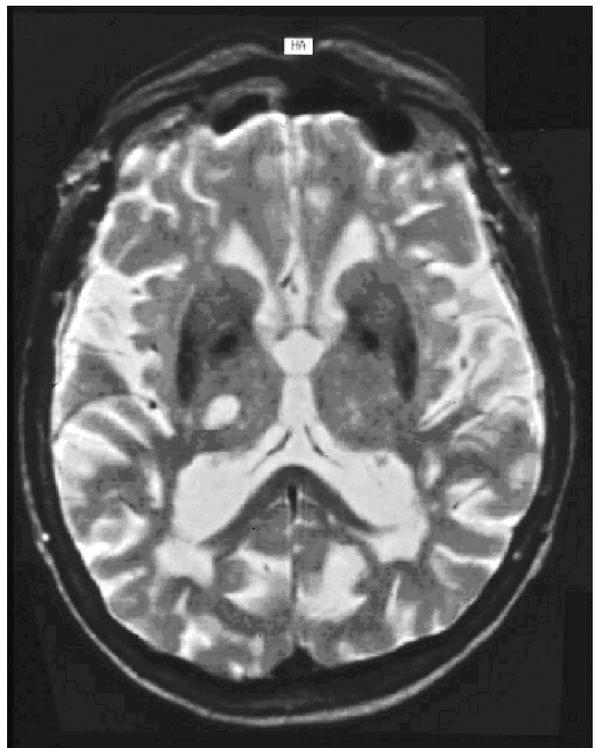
A right inferolateral thalamic infarct (MRI T2-weighted imaging).
